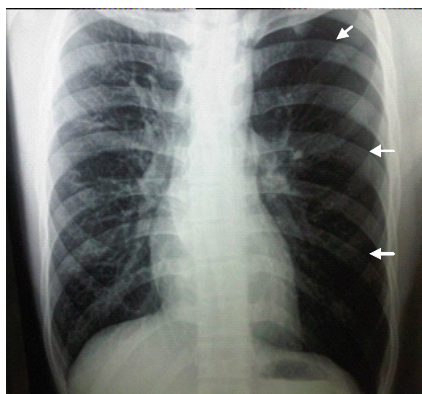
Third chest X-ray (arrows pointing pleural line)
